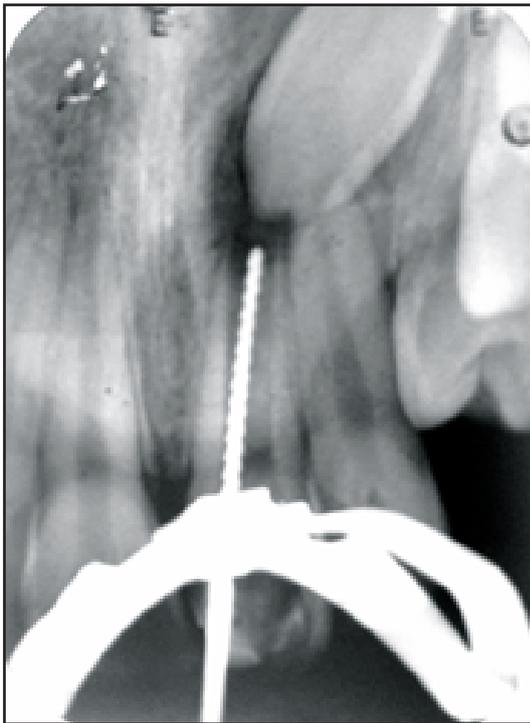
A Radiograph revealing #40 k-file extending for the intentional bleeding.
